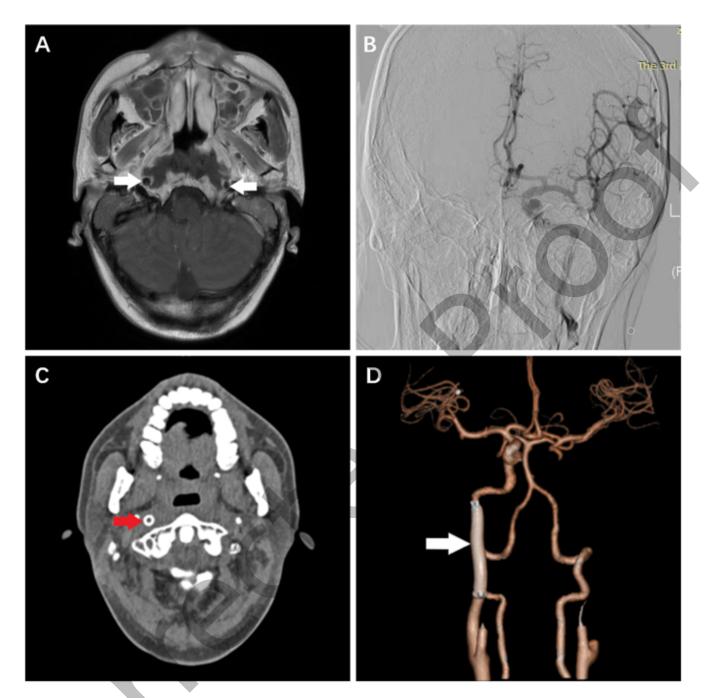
Imaging findings of ICA stents. (A) Horizontal enhanced MRI shows that the ICA was exposed to PRNN. (B) Cerebral angiography shows a positive BOT result. (C) Stents are observed on coronal enhanced CT scans. (D) CT scan with 3D reconstruction showing the location of the ICA stent.
